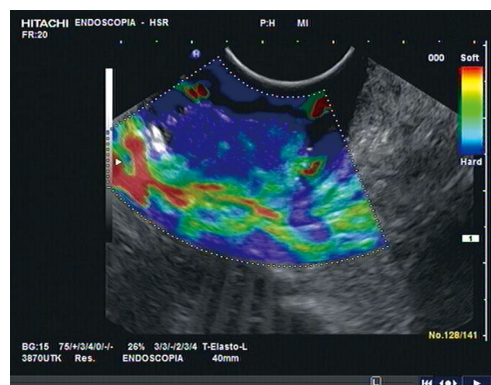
Rectal EUS and elastosonography before neoadjuvant chemoradiation treatment. Elastography showing hard tissue inside the lesion.
